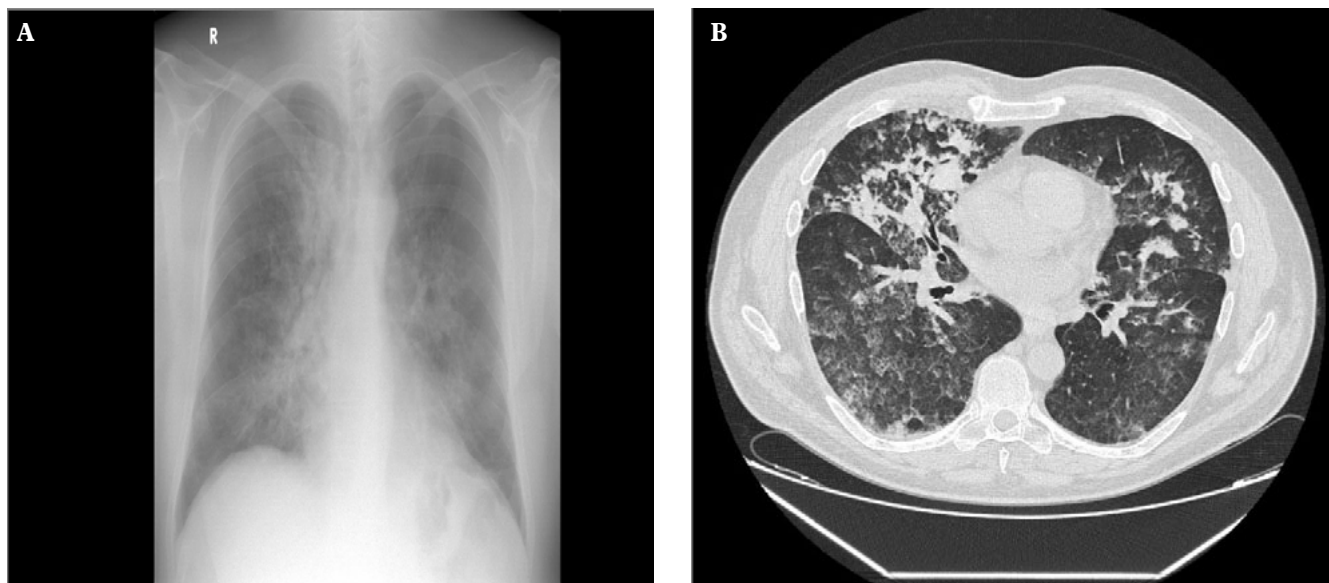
X-ray chest (A) and CT (B) on admission to the Department of Pulmonology: ‘frozen glass’ type infiltration in the parenchyma of both lungs – bleeding into the alveoli.
